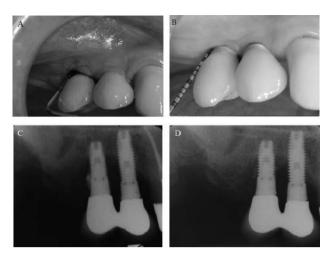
A) Buccally, probing depth (PD) is about 10 mm in the distal site of the most posterior maxillary implant, BoP positive and exudate is present. B) The same site 6 months later. The peridontal probe measures 2 mm PD. The tissue surrounding the implant seems to offer better clinical stability, compared to initial evaluation. C) On the periapical radiograph, residual cement is visible distally to the most posterior maxillary right implant. A significant bone loss is detectable around both implants. D) Periapical radiograph, six months later.
